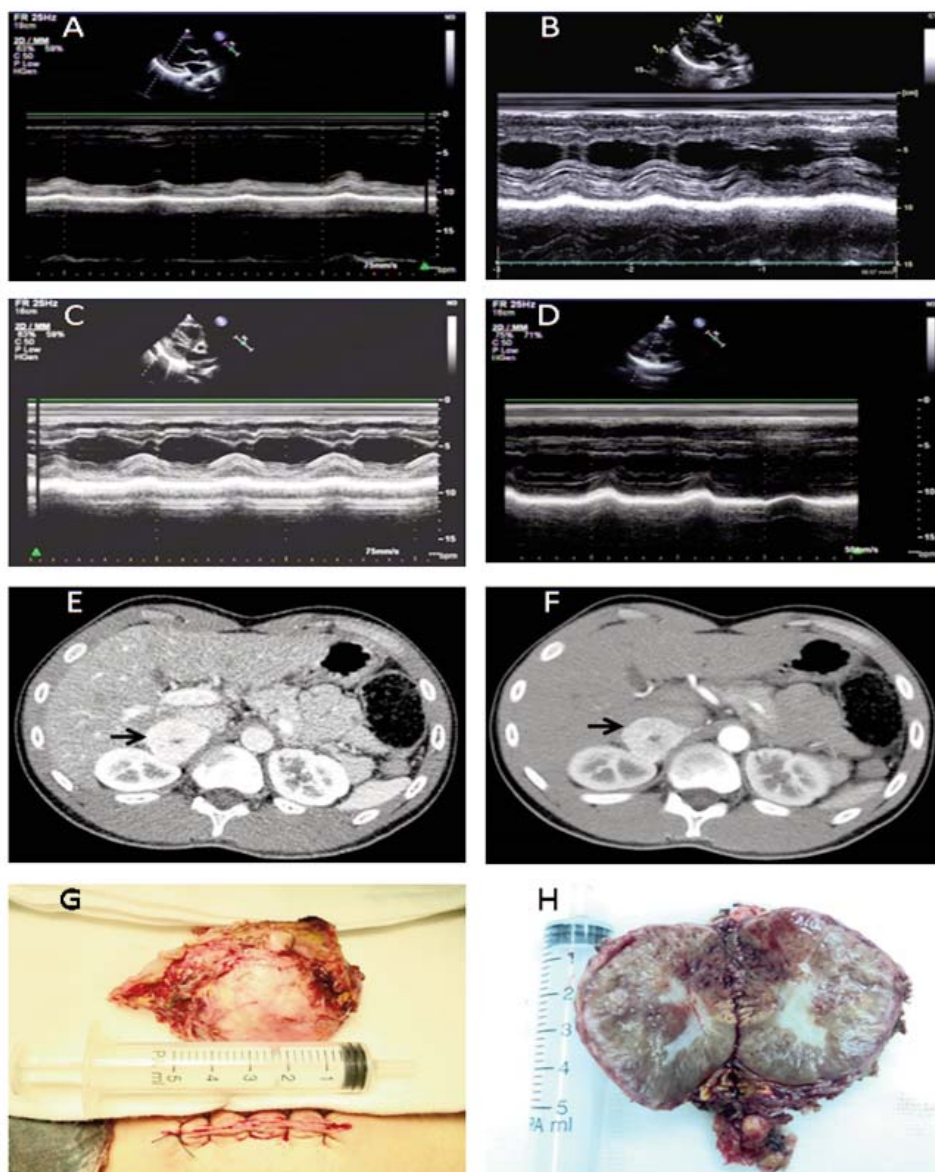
Echocardiography in parasternal long axis view of heart and abdominal computed tomography (CT) scan. Echocardiography performed on (A) April 12, 2017, [left ventricular end-diastolic dimension (LVEDD) 58.2 mm, left ventricular ejection fraction (LVEF) 30%];(B) October 18, 2017, (LVEDD 49.0 mm, LVEF 56%); (C) October 17, 2018, (LVEDD 48.0 mm, LVEF 52%); and (D) June 10, 2019, (LVEDD 45.0 mm, LVEF 65%). (E) Plain CT showing a 39×33×41mm well-defined and uniform density mass in the right adrenal region (arrow). (F) Results of contrast-enhanced CT (arrow). (G, H) Macroscopic anatomy image of the right adrenal mass after laparoscopic adrenalectomy.
